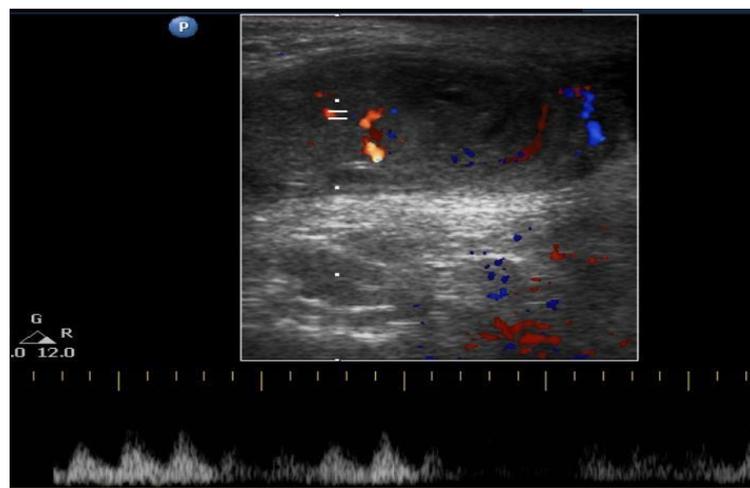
Scrotal ultrasound - Right testis longitudinal view. Right testicle is in the scrotum and measures 1.7 x 0.9 x 0.9 cm with normal vascular flow (green arrow). Thickened, echogenic, hypo vascular right epididymis (yellow arrow).
